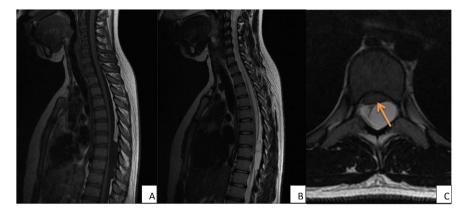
Medullary MRI in sagittal T1-weighted sections in hypointense (A), hyperintense in T2 (B), and axial T2 (C) showing an extensive dorsal posterior cystic formation from D7-D10, with a signal identical to that of the CSF without enhancement after gadolinium injection.
